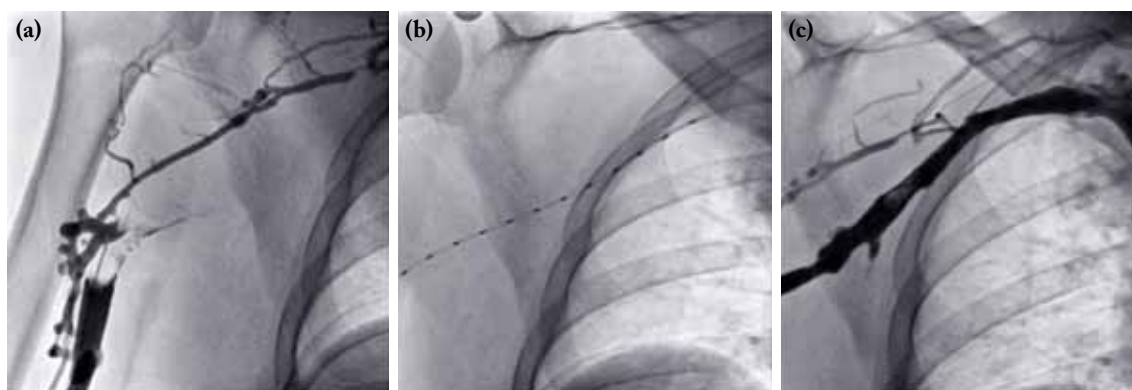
(a) Venography showing the absence of filling of the subclavian and brachiocephalic vein, consistent with thrombosis. (b) EKOS catheter with a 30 cm treatment length was placed into the thrombus (note the radiopaque ultrasound transducers). (c) Final venogram showing complete resolution.
